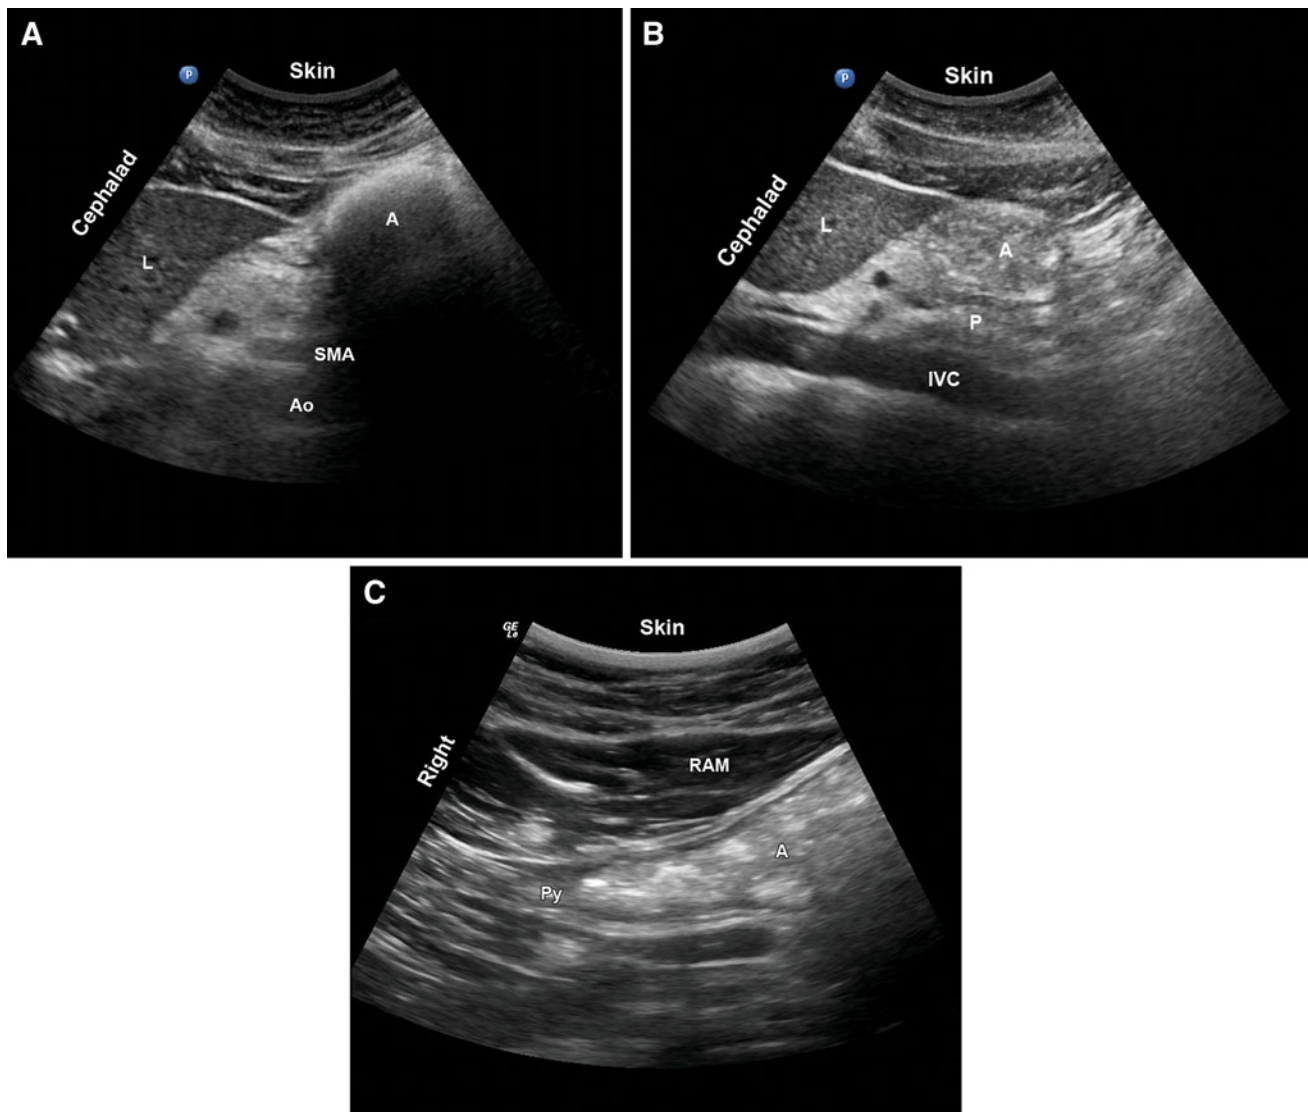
A Sagittal sonogram of the gastric antrum (“frosted glass” appearance) five minutes after ingestion of a solid meal. A = antrum; L = Liver; SMA = superior mesenteric artery; Ao = aorta. B Sagittal sonogram of the gastric antrum with hyperechoic content 90 min
